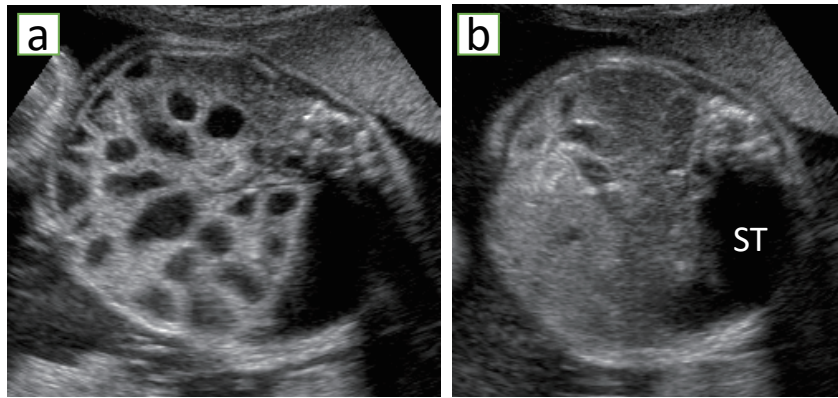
Ultrasonographic images at 29 weeks of gestation: (a) Diffuse dilated bowel loops resembling the structure of a honeycomb or beehive (the “honeycomb” sign) and (b) a slightly enlarged stomach (ST).
